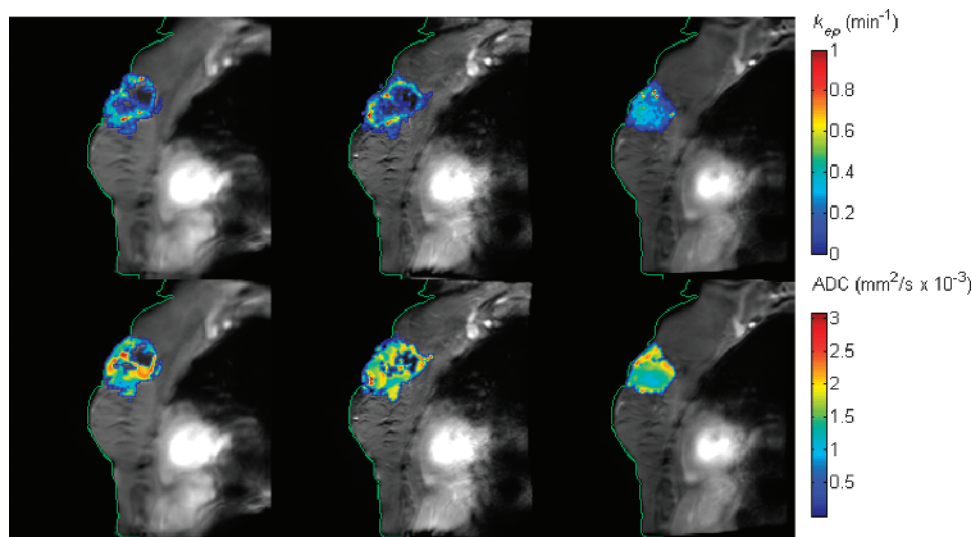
The  $k_{ep}$  (top row) and ADC (bottom row) maps superimposed on the postcontrast DCE-MRI data pre-NAC (first column), post-one cycle of NAC (second column), and post-all cycles of NAC (third column) for one patient achieving pCR. Multiparametric maps at different time points were all registered to a common space. The green contour was drawn on the images at  $t_3$  and copied to the images at the other time points. The well-aligned contours at all three times indicate the accuracy of the temporal alignment of the images. (The area of nonspecific enhancement seen in the medial quadrant of the breast at  $t_3$  was biopsied and found to reveal only benign fibrocystic changes.)
